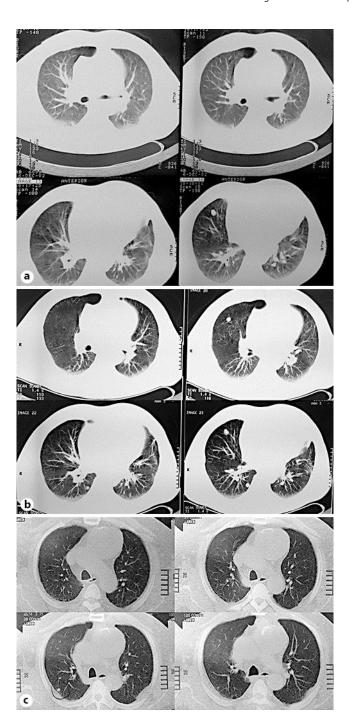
CT scans of a long-term NSCLC survivor $\bf a$ after chemotherapy (CT of the thorax was assessed as 'normal' – the lesion in the right upper lobe was assessed as calcified), $\bf b$ during disease progression and $\bf c$ during stable disease after long-term treatment with erlotinib.
